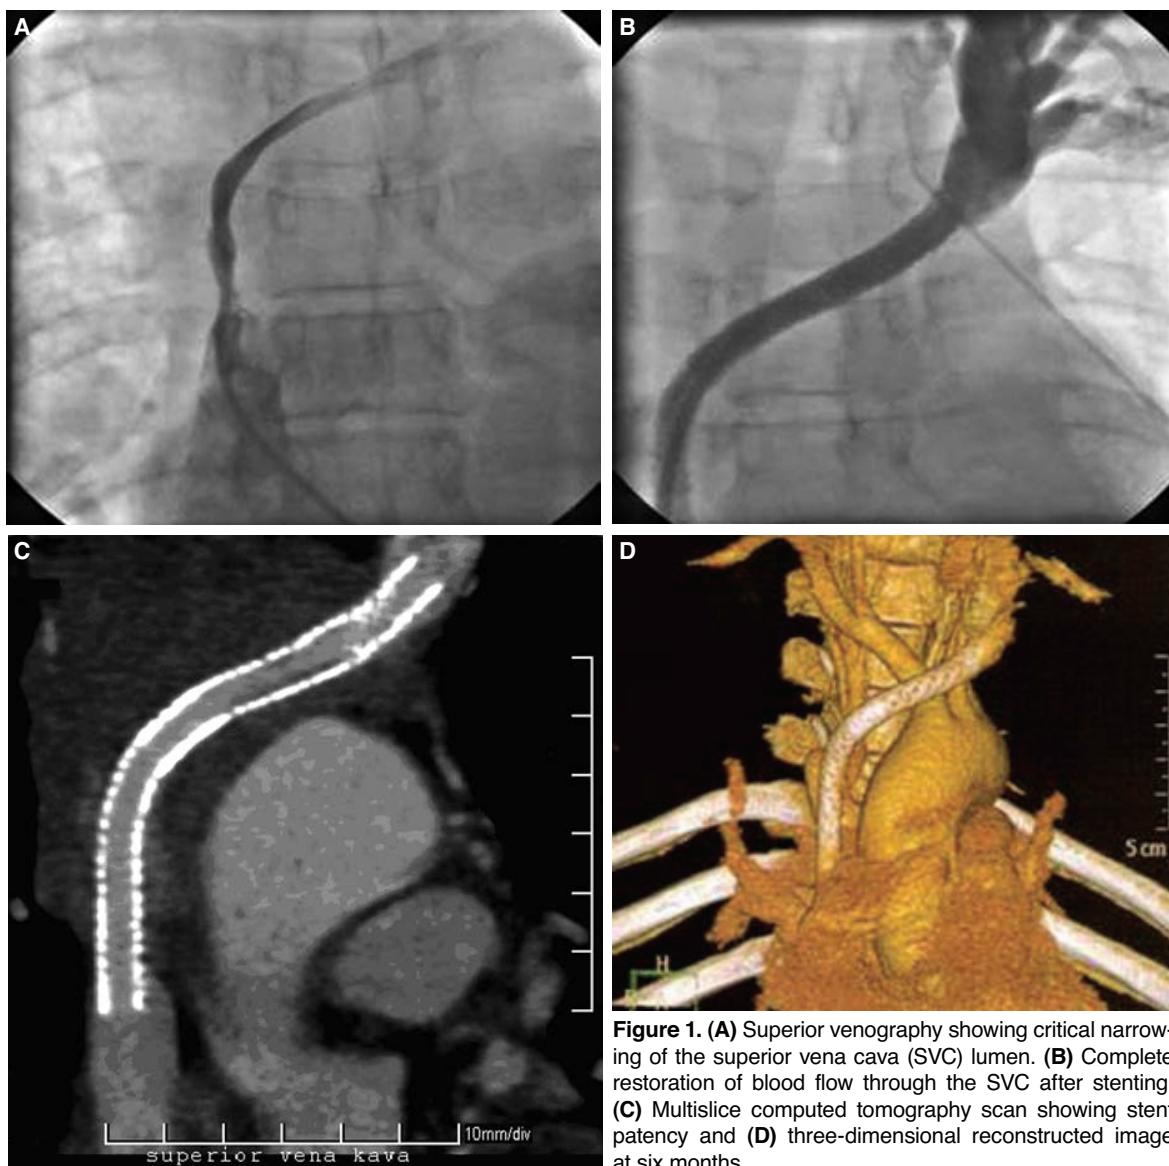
(A) Superior venography showing critical narrowing of the superior vena cava (SVC) lumen. (B) Complete restoration of blood flow through the SVC after stenting. (C) Multislice computed tomography scan showing stent patency and (D) three-dimensional reconstructed image at six months.
